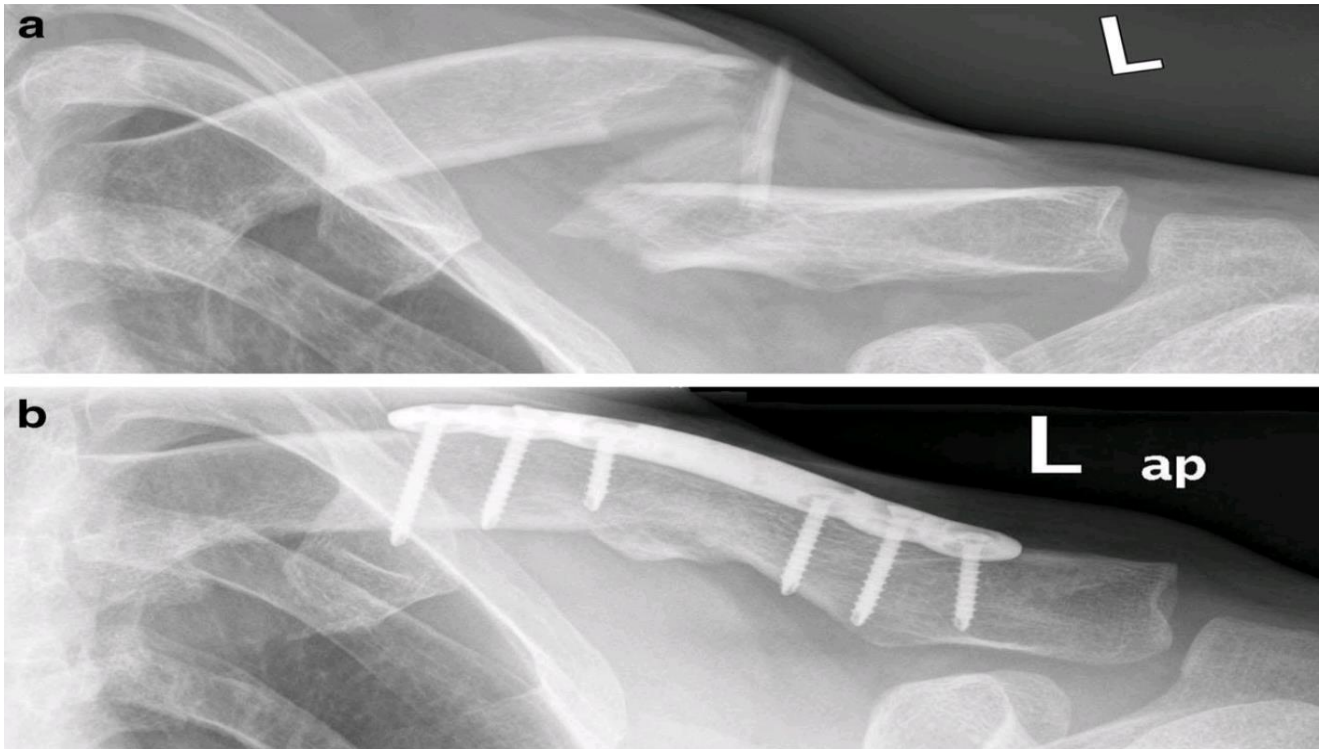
A pre & post operation x-ray of left mid-shaft clavicle fracture treated surgically by plate and screw fixation ⁽²⁰⁾ ⁽²¹⁾.
